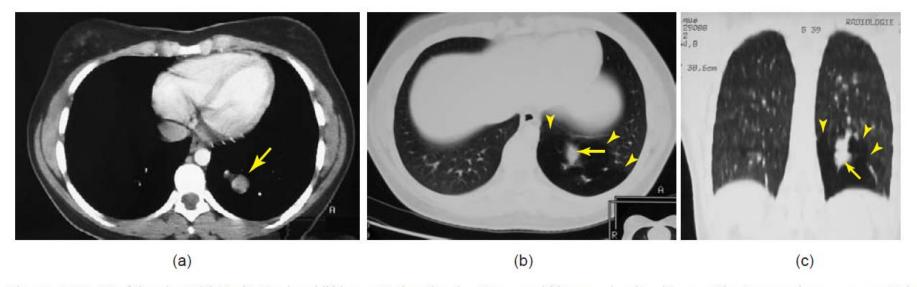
CT of the chest. (a) Mediastinal and (b) lung window/level settings, and (c) coronal resliced image. The images show a congenital malformation of the lung located in the left lower lobe. Notice the two components of the lesion: a dense multilobular opacity (arrow) surrounded by an area of decreased lung attenuation (arrow heads). (Courtesy of Professor J. Verschakelen, Department of Radiology.)
